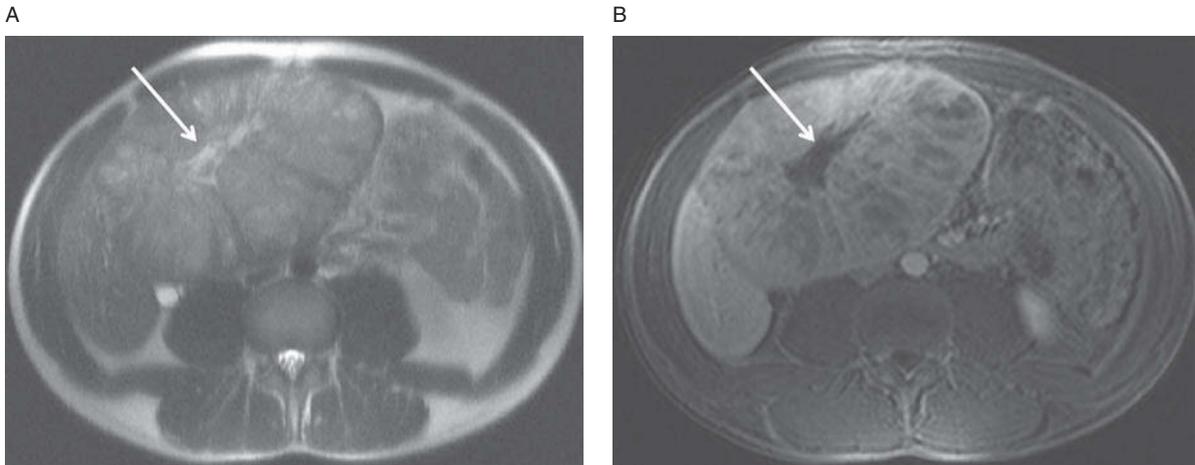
Fibrolamellar HCC. Axial T2-weighted image (A) demonstrates heterogeneous lesion within the liver. Arrow denotes T2-bright scar. Axial, T1-weighted, fat-saturated post-contrast image (B) demonstrate same heterogeneous lesion with areas of hypervascularity. Arrow again denotes central scar. Note lack of enhancement of central scar. The scar in FNH typically shows delayed enhancement.
